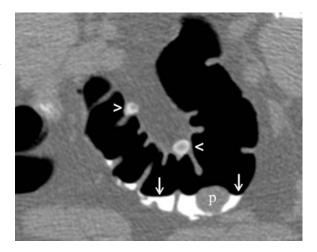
Axial CT scan through the sigmoid colon. Image shows high-density fluid tagged with iodine (*arrows*) and a 15 mm polyp (*p*) clearly depicted due to its soft-tissue attenuation. Two fluid-filled diverticula can be observed on the opposite wall (*arrow-points*)
